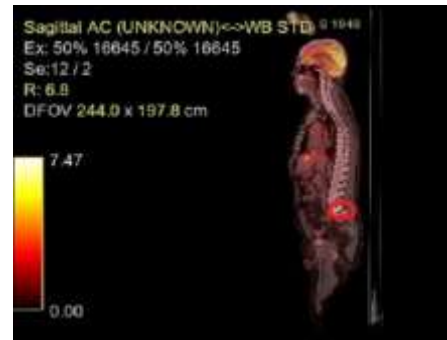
Secondary bone determination of L5, on PET-CT
